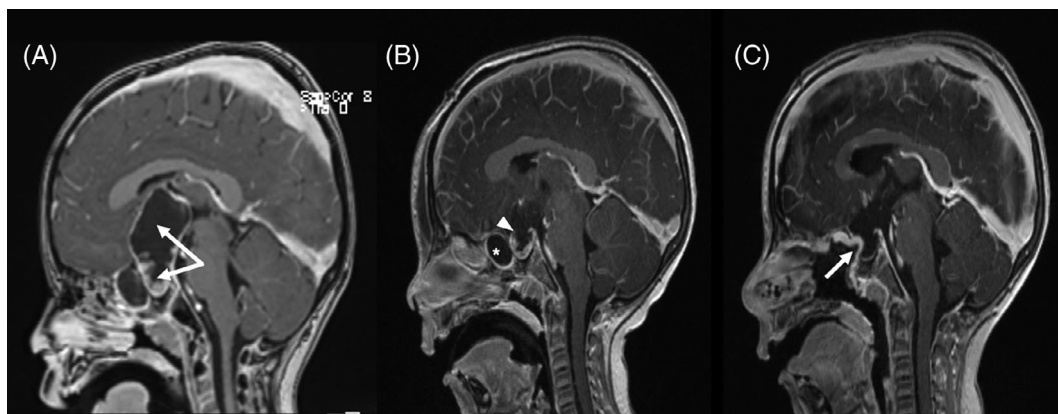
Large cystic craniopharyngioma requiring open and endonasal approaches for resection. A, Preoperative magnetic resonance imaging (MRI) demonstrating extensive sellar, suprasellar, and intraventricular extension (arrow). Staged combined modality resection was selected. B, MRI following pterional craniotomy and resection of intraventricular and suprasellar component with remnant sphenoid (asterisk) and intrasellar (arrowhead) component. C, Postoperative MRI demonstrating gross total resection and good position of nasoseptal flap (arrow)
